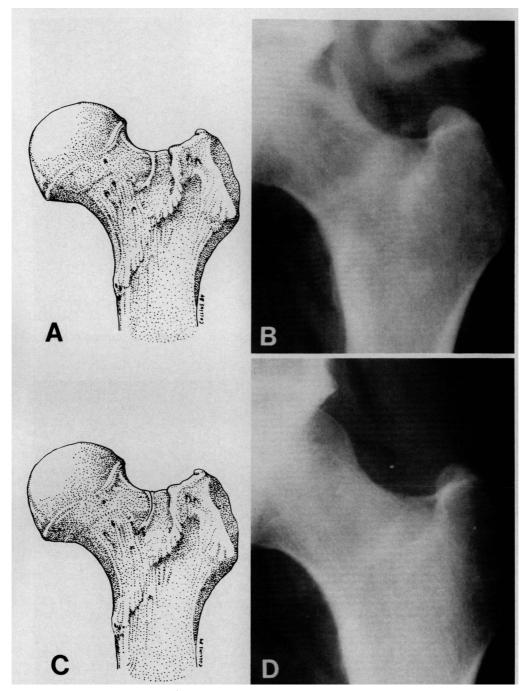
A, location of tension-side stress fracture sclerosis. B, tension-side stress fracture manifested by sclerosis on the radiograph. C, tension-side stress fracture demonstrated by a cortical crack. D, radiograph of undisplaced crack in the tension side of a femoral neck.
